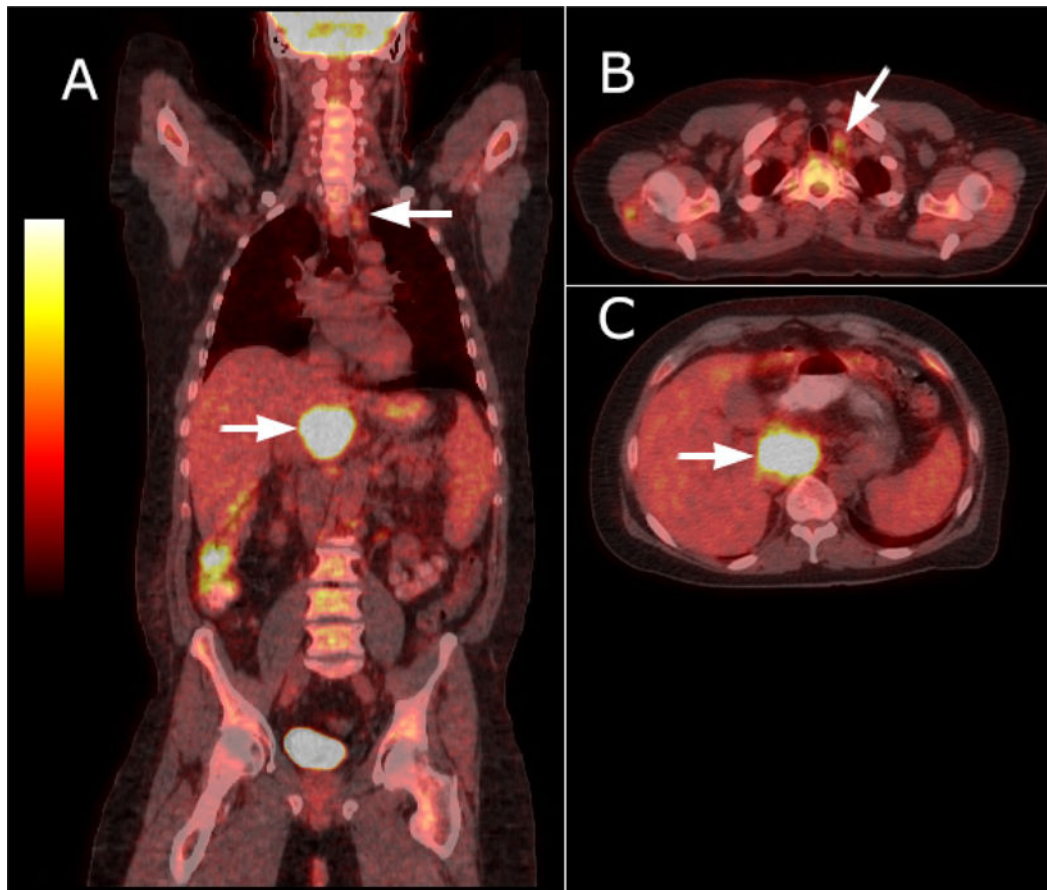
Whole body CT-PET fusion imaging findings: there is focal intense FDG uptake of portacaval lymph node measuring 43×64 mm. Max SUV 16.5 (Figure, A). Inserts show fused CT-PET coronal image of hypermetabolic hepatic artery lymph node (Figure, B) and mildly hypermetabolic left superior para-tracheal node measuring 10×13 mm. Max SUV 3.1 (Figure, C)
